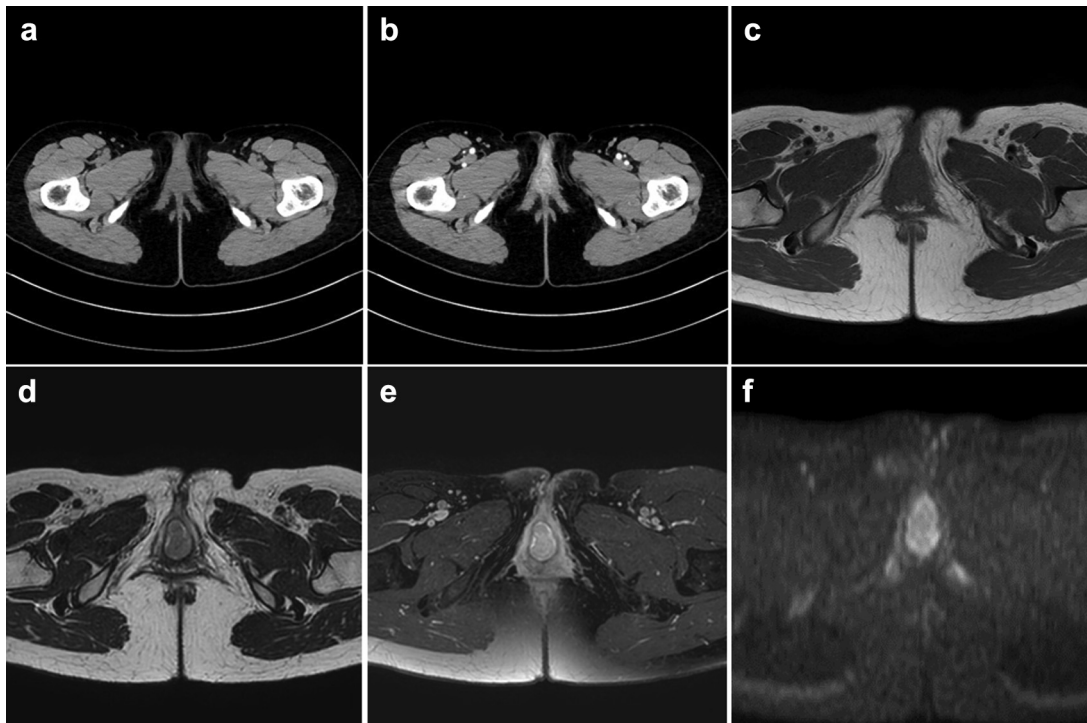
Pelvic CT and MRI findings. CT appearances. A Soft tissue density mass with homogenous contrast enhancement is seen at the external urethral meatus (a,b). MRI appearances. On a T1-weighted axial image, the mass shows intermediate signal intensity (c). On T2-weighted image and diffusion-weighted image, the lesion demonstrates slightly hyper-intensity (d,e). Homogenous contrast enhancement is observed (f).
